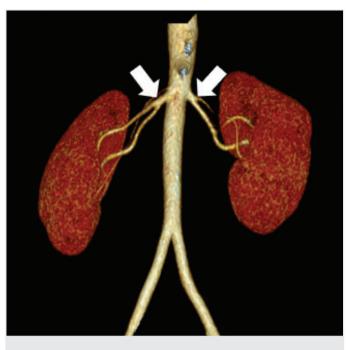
Three-dimensional computed tomography reconstruction of the renal arteries; early division point of the renal artery (arrow)
